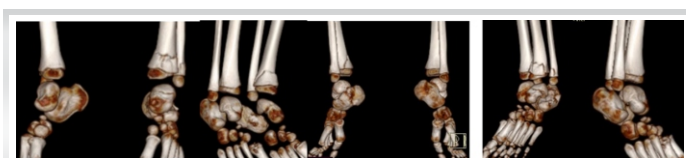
3D reconstruction computed tomography scan of bilateral foot and ankle.
